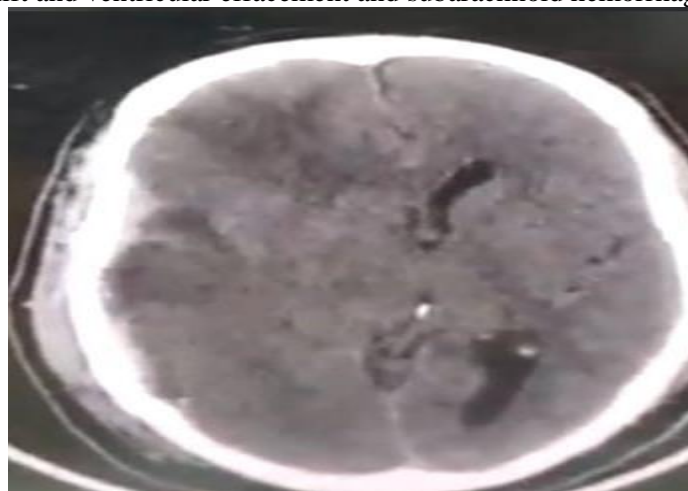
CT Brain showing multiple brain contusions, subdural hematoma with midline shift, ventricular effacement and subarachnoid hemorrhage. On follow up of the patient after admission GCS of the patient deteriorated.
